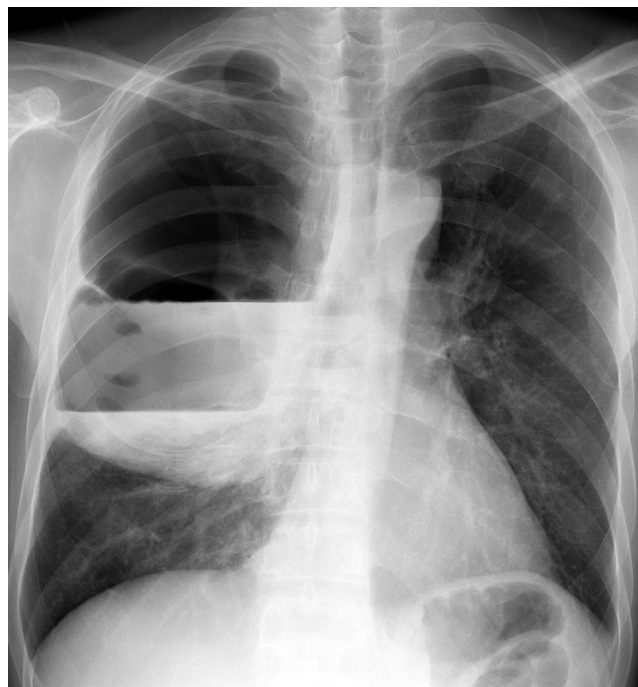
Air-fluid levels in giant bullous emphysema with superimposed infection in a 48-year-old man. Plain radiography shows 2 air fluid levels within a large transradiant vascular area with diffusely thickened walls. The volume of the avascular area is over two-thirds of the right lung.
